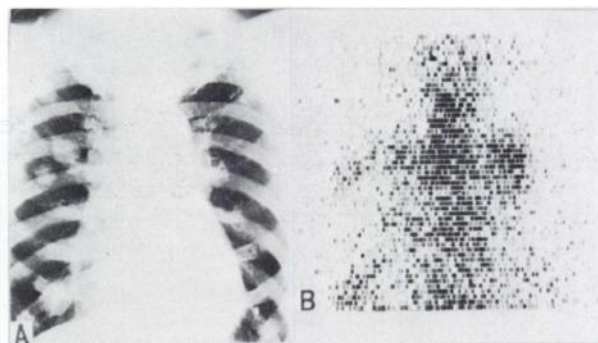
(A) Chest x-ray shows round shadow in right middle and lower lung fields and left hilar region. (B) Scintigram is positive even with tumor shadow 1.5 cm in diam.
